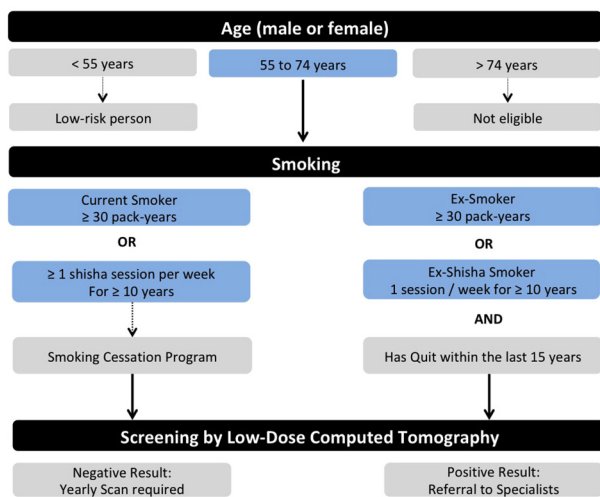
Pathway for the identification of the individuals eligible for lung cancer screening by low-dose computed tomography scan in the Lebanese population.
